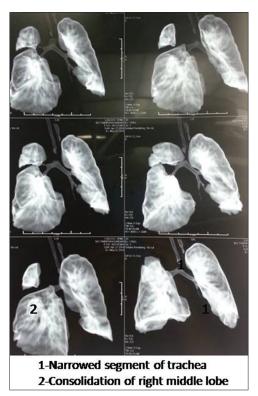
Dynamic computed tomographic scan showing narrowed trachea and consolidation
